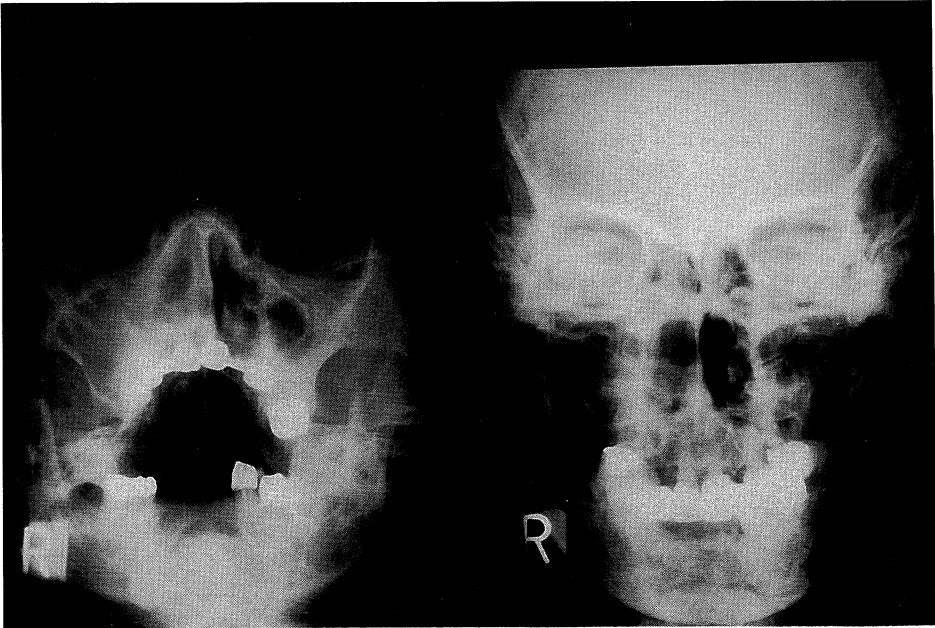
4 Plain x-ray examination and tomography of the nose showed only a right-side shadow
